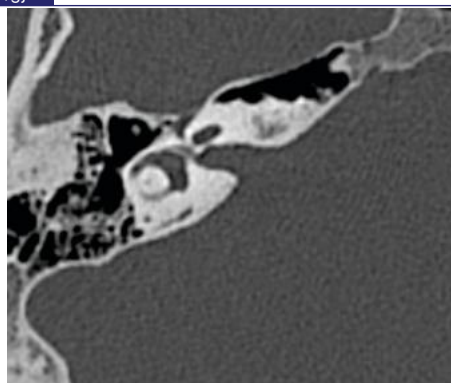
Computed Tomography Image Showing the Bud Shape of the Internal Acoustic Meatus
